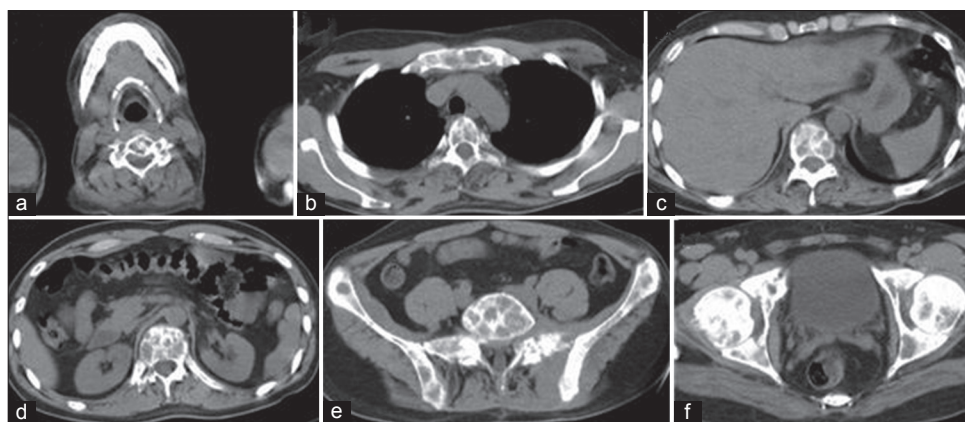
CT scan of spine of case two showing multiple osteolytic lesions in cervical. (a) upper thoracic and sternum (b) Lower thoracic (c) Lumbar (d) Sacrum and pelvis (e) and head of femur (f)
